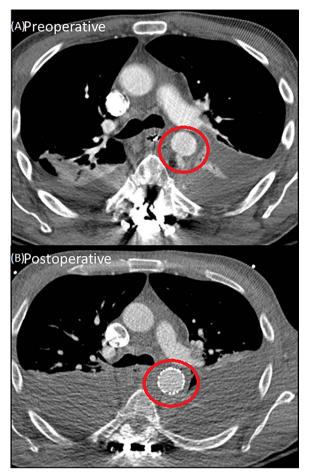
Pre/postoperative CT angiograms demonstrating thoracic aortic pseudoaneurysm and repair.
